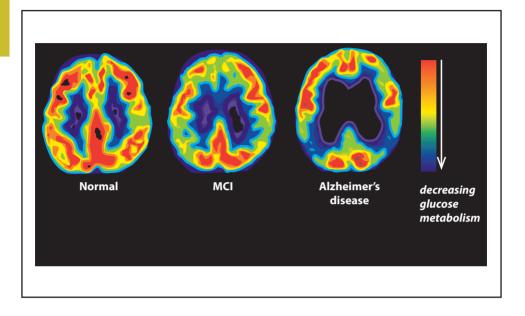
18F-2-Fluoro-2-Deoxy-D-Glucose positron emission tomography (FDG-PET) measures glucose metabolism in the brain as an indirect measure of synaptic activity. The FDG-PET abnormalities seen in patients with AD may reflect a number of factors in the brain including mitochondrial dysfunction, oxidative stress, aberrant synaptic plasticity, glial activation and inflammation, reduced cerebral blood flow, and synaptic dysfunction of neuronal death (Johnson et al, 2011).
